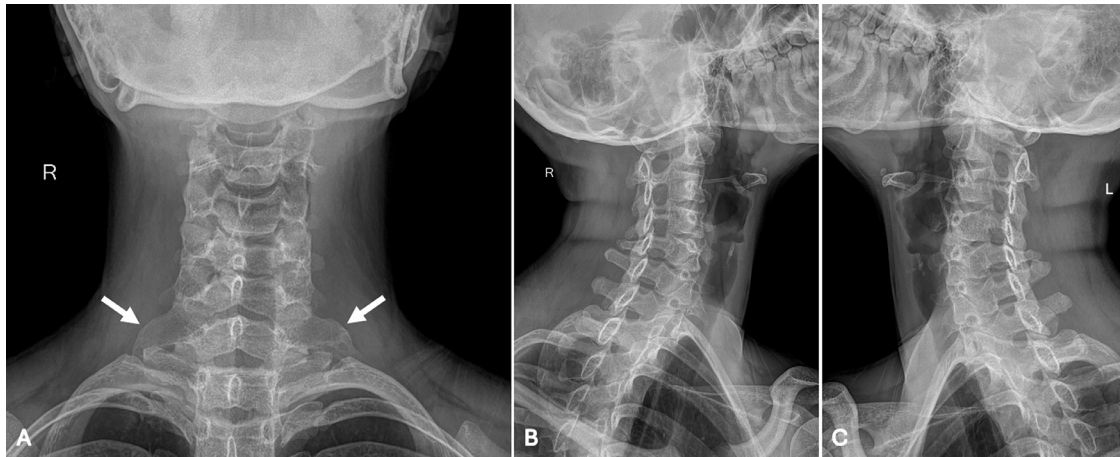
The cervical spine radiograph in anteroposterior views (A) showed elongated C7 transverse processes on both sides (arrow). No foramen stenosis on bilateral oblique cervical spine radiographs (B: right side, C: left side).
